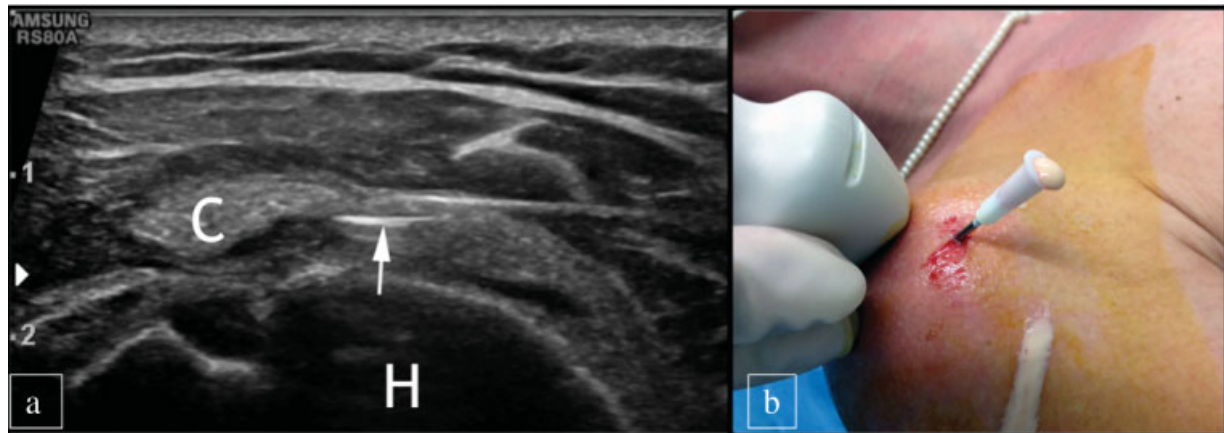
(a) Ultrasound image of a calcification with soft consistency punctured with a single-needle technique. (b) Immediately after the insertion of the needle into the calcification, a leakage of white material may be seen from the needle, representing the amorphous content of the calcification. C = calcification, arrow = needle, H = humeral head.
